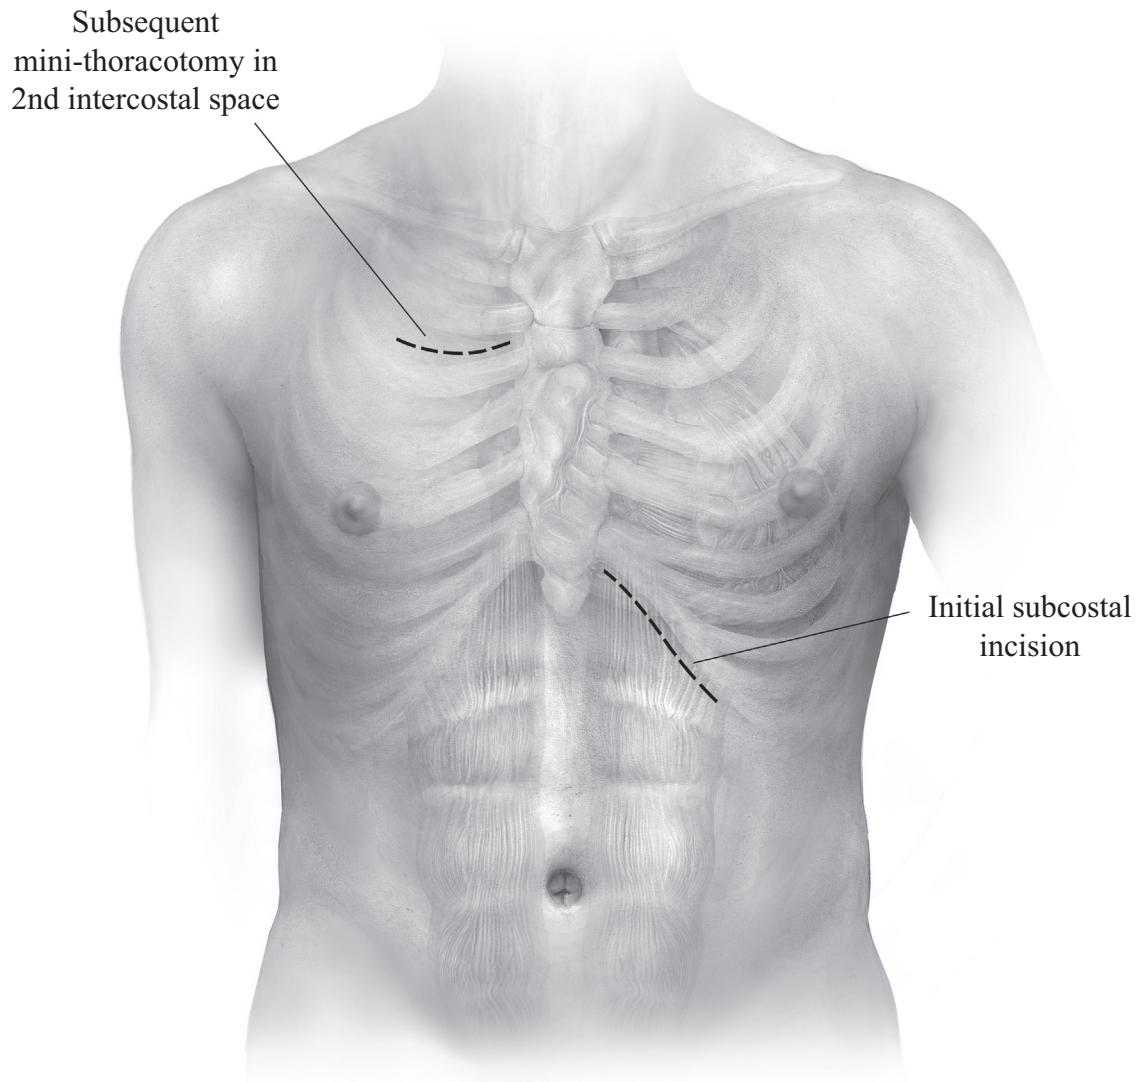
Anesthetic and surgical preparation is same as for implantation of HeartMate II through sternotomy. General anesthesia with a single lumen endotracheal tube is used. A transesophageal echocardiogram is performed to confirm that there are no valve dysfunctions or structural lesions that need surgical correction (if there are structural or valve lesions that need correction, then this technique is contraindicated, and the device should be implanted via median sternotomy to allow cardiac repair). External defibrillator paddles are placed. If the patient has an internal defibrillator, this is left active, as it may be used as a defibrillator later in the operation. A sterile magnet is placed over the device after draping to prevent interference by diathermy. The patient is placed in a supine position and prepared and draped as for a median sternotomy. A typically 8-12 cm long left subcostal incision is made, starting approximately 2 cm lateral to the xiphoid process and then extended laterally. The incision is deepened through the subcutaneous layers with cautery.
